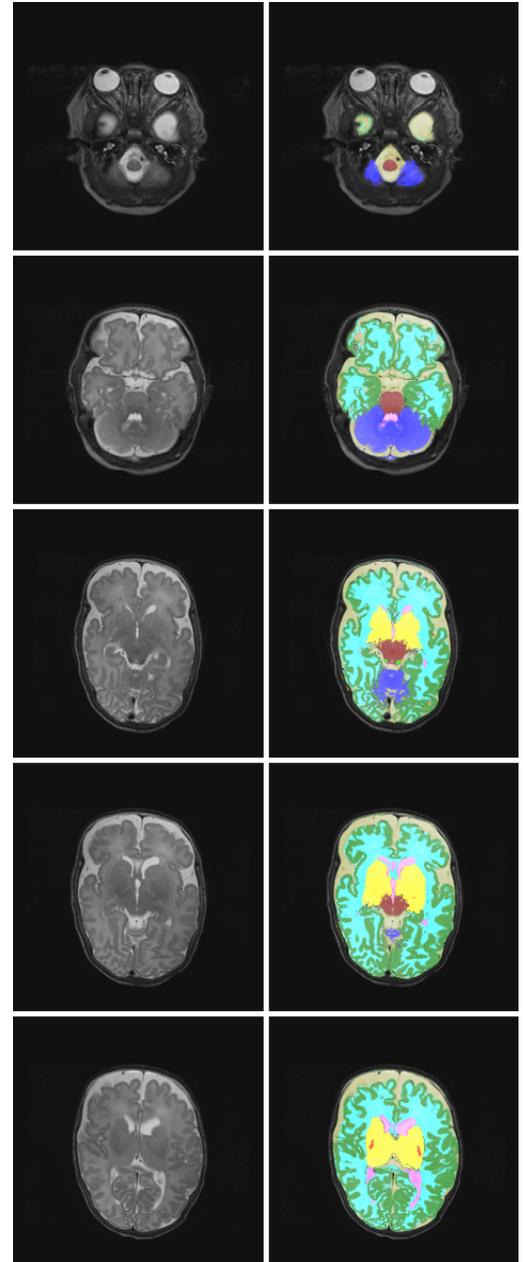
T2-weighted MRI and segmentation of nine tissue types in different regions of the neonatal brain.
